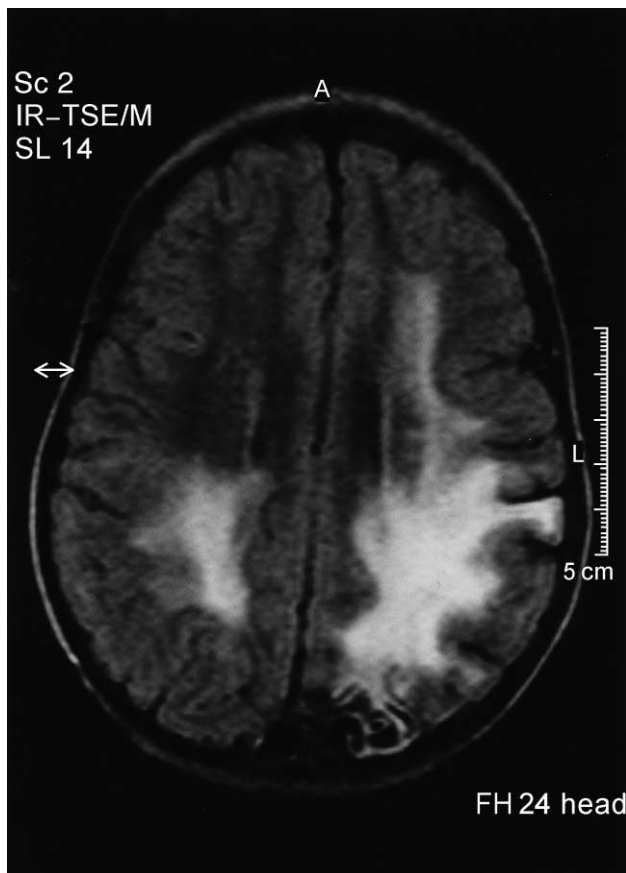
MRI of Patient 2 (T2-weighted FLAIR) showing left-sided parieto-occipital necrosis with marked bilateral white matter lesions 11 weeks after admission before the second course of steroid treatment.
